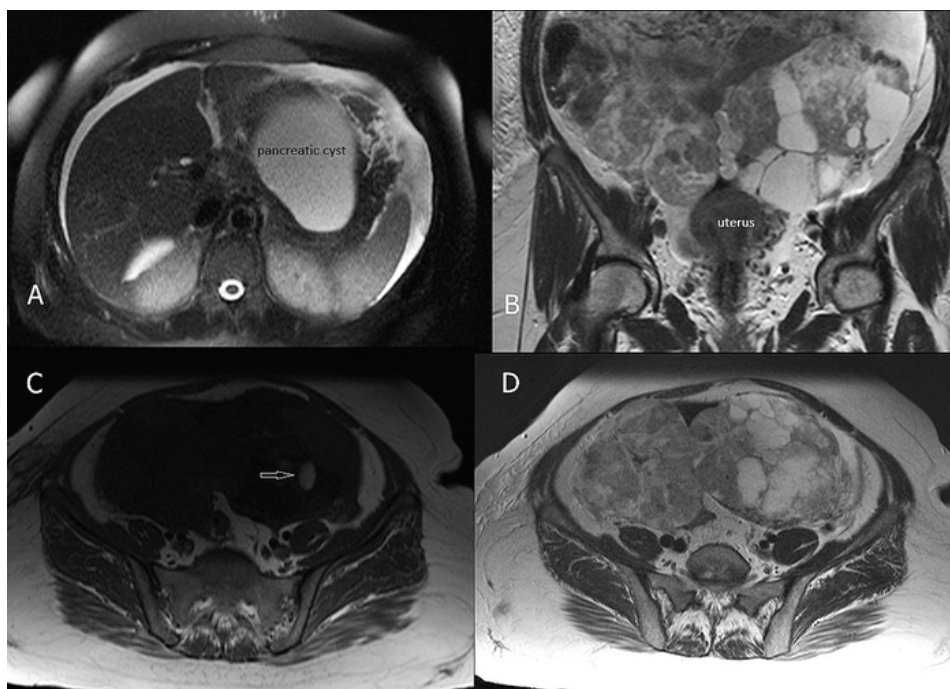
Magnetic resonance imaging findings: A) The local tumor mass was not seen at the site of the cholecystectomy. The T2w FS image reveals ascites as well as the presence of a big, encapsulated, well-defined, cystic mass in the pancreatic tail; B) Bilateral ovarian tumor masses, multilocular and with thick septa, of inhomogeneous signal intensity are seen in a coronal T2w image. Both tumor masses are well delineated without infiltration of adjacent structures; C) An axial T1w FS image showed the presence of small areas of haemorrhage in the tumor mass (indicated by an arrow); D) No enlarged parailiac lymph nodes are noted on the axial T2w image.
